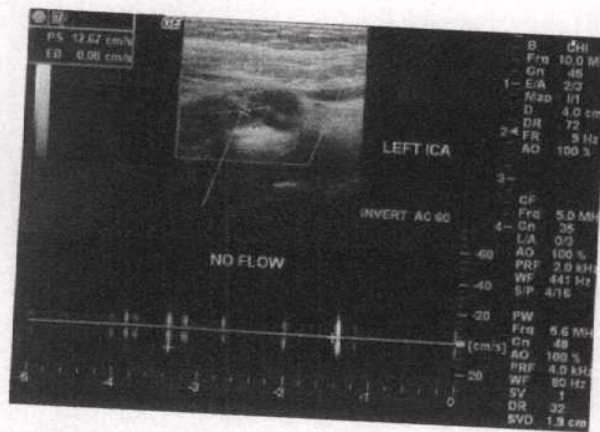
d): No Doppler signal waveform of Lt ICA.
